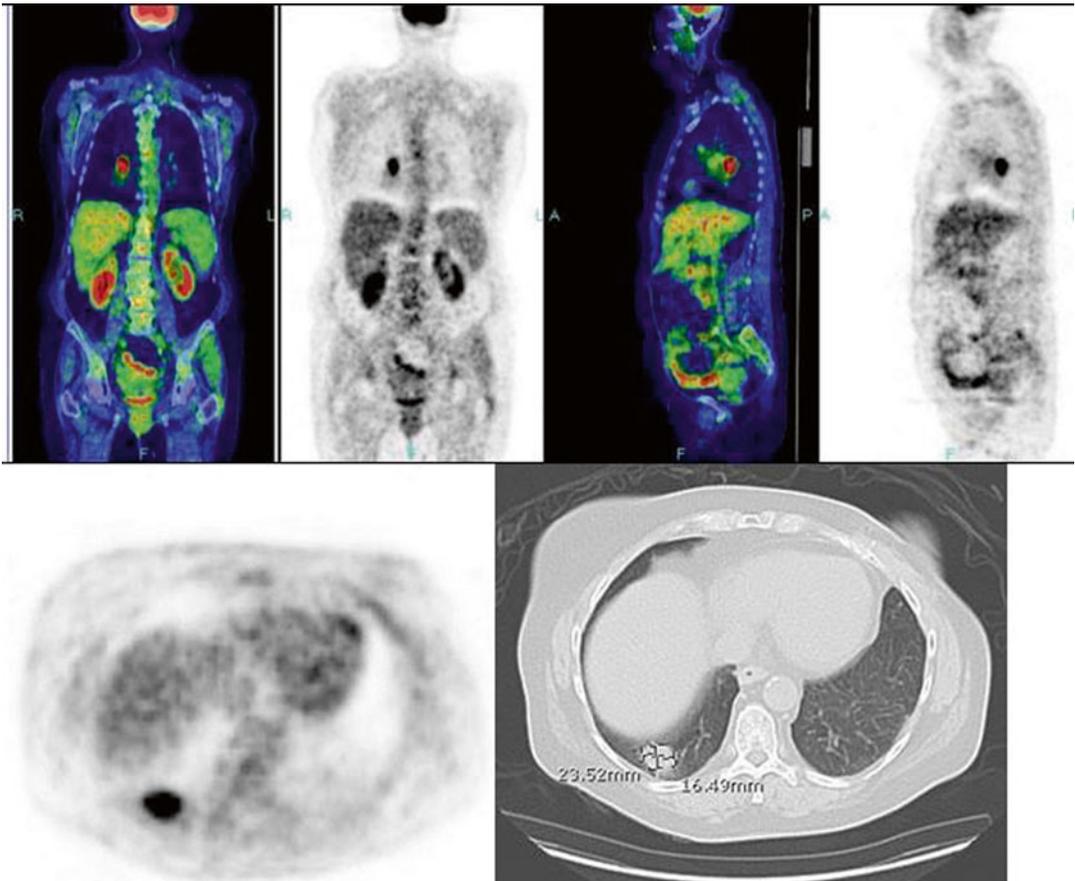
PET/CT (pretreatment)
